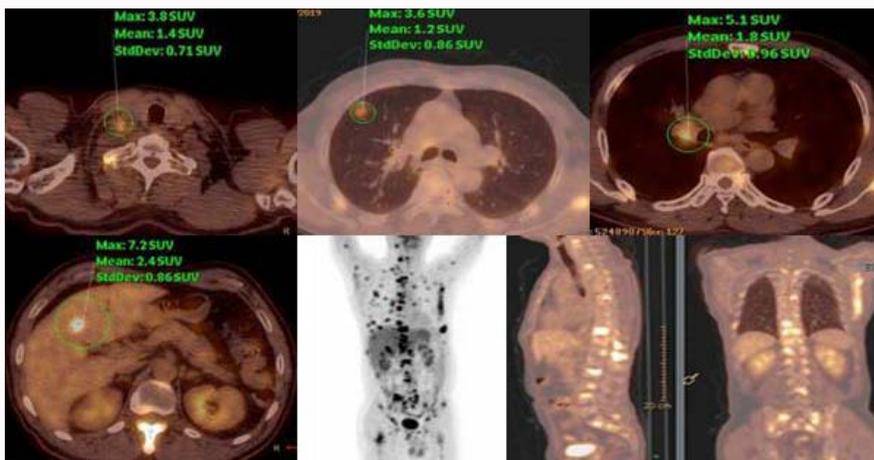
The result of PET-CT in 2019.
